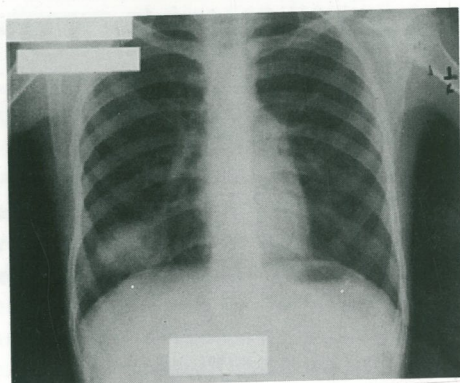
Chest-X-ray of a 12 yr old boy showing Right Lower Lobe Pseudotumor
